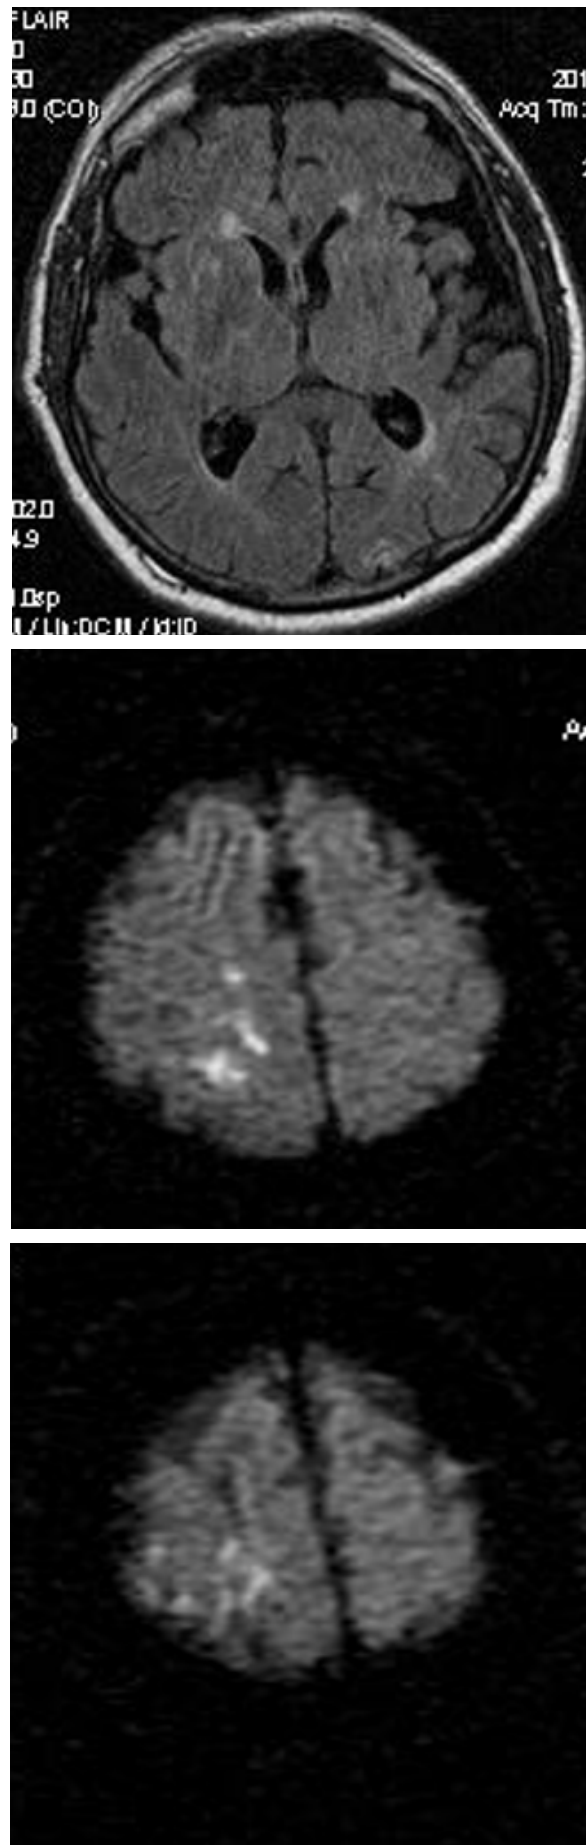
Postoperative structural neuroimaging and electrophysiological dynamics. Axial T2-FLAIR and DWI sequences demonstrating subclinical, silent microischemic foci within the periventricular white matter and hippocampal regions post-cardiopulmonary bypass.
